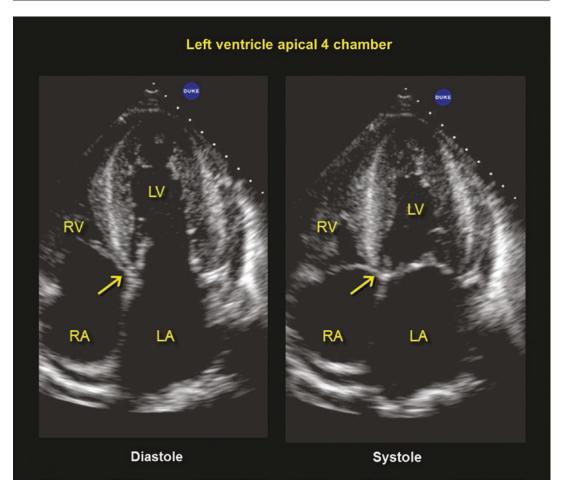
Two dimensional echocardiographic images in diastole and systole oriented in the apical four chamber view for comparison. The arrow points to the atrio-ventricular septum
